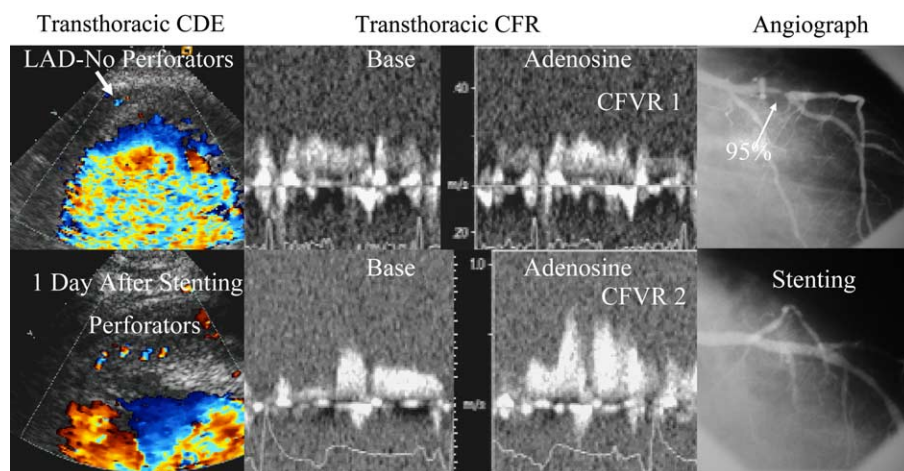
Patient with acute anterior myocardial infarction treated with intravenous thrombolytics 30 min after the onset of symptoms. Upper panels: Transthoracic coronary Doppler echocardiography (CDE) failed to show recanalization of perforators in the territory of the left anterior descending (LAD) coronary artery. CFVR was 1, and coronary angiography showed LAD subocclusion. Lower panels: After successful LAD stenting there was an early restoration of perforators' patency in the anterior apical wall and a marked improvement in LAD flow (CFVR = 2), predicting recovery of wall motion at follow-up. Modified from reference.⁷³
